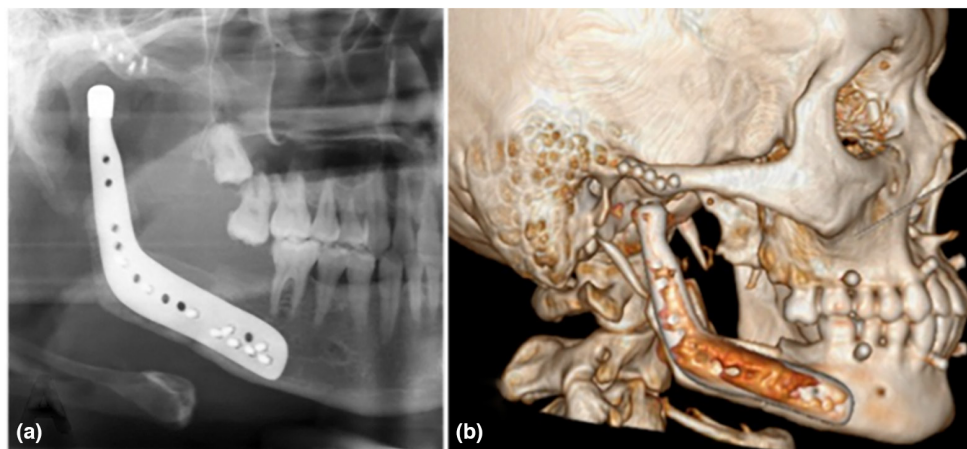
Radiographic examination after surgery. (a) OPG. (b) CT model.
